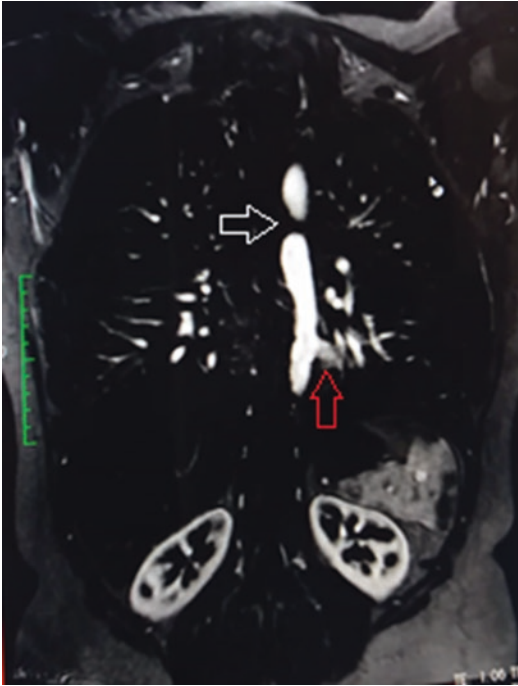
MRI shows the aortic arch interruption at the aortic isthmus level (*white arrow*) and the end-to-side anastomosis between the Goretex graft and descending thoracic aorta (*red arrow*)
